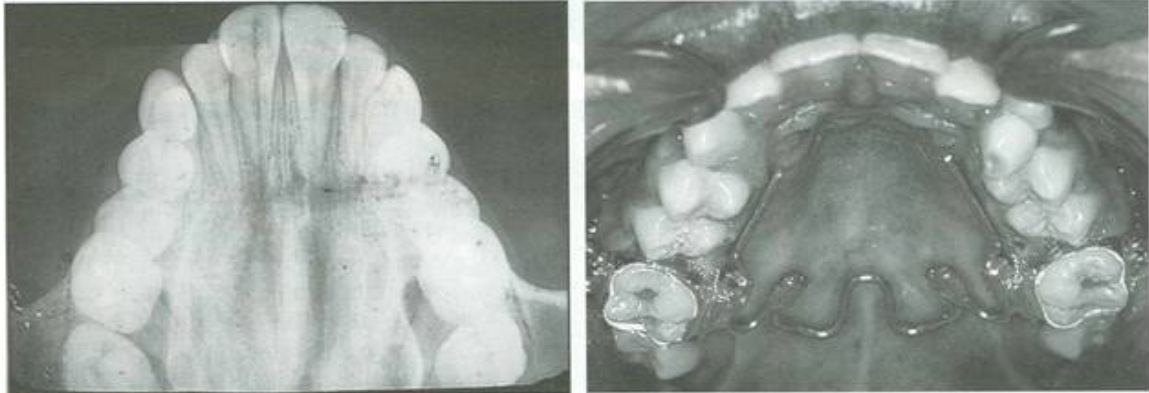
Case 1. Palatal x-ray and NPE2 at initial placement.
